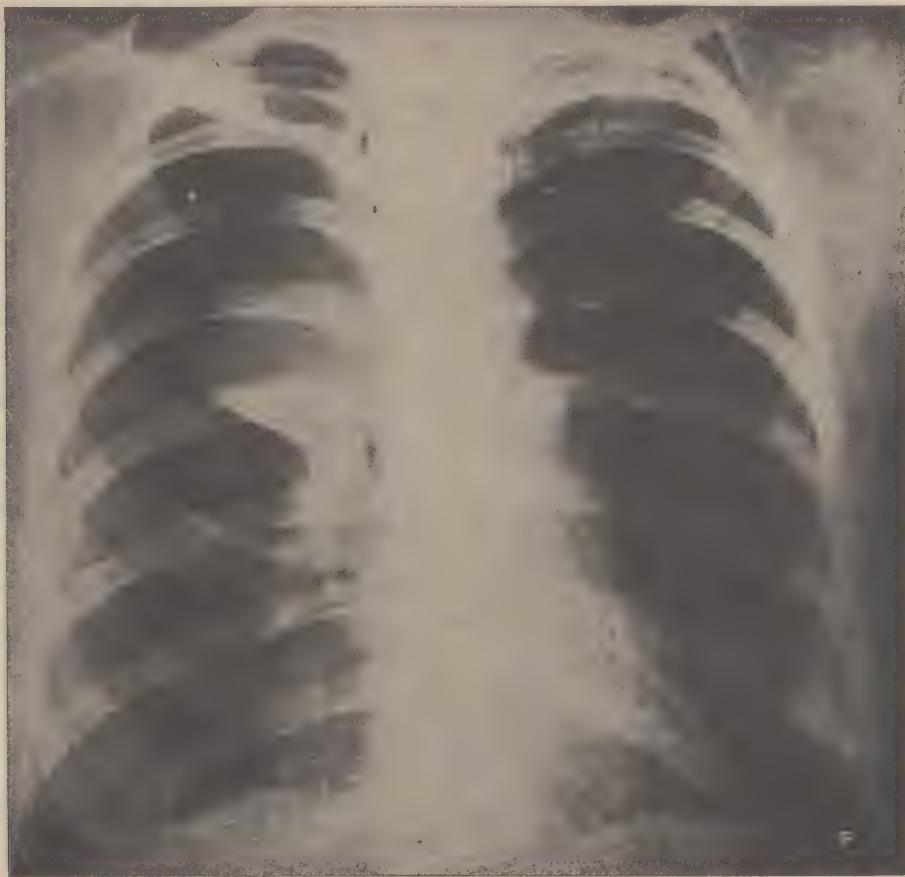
Preoperative film. This roentgenogram is identical in appearance with one taken two days after the induction of artificial pneumothorax.
